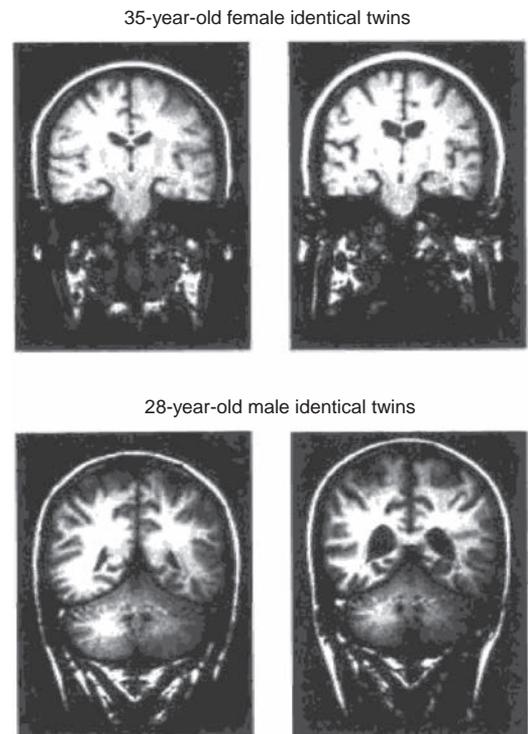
• Coronal magnetic resonance imaging of two sets of twins discordant for schizophrenia. The enlarged lateral ventricles are readily apparent in the subjects on the right. (Courtesy of Drs. E. Fuller Torrey and Daniel Weinberger.)
